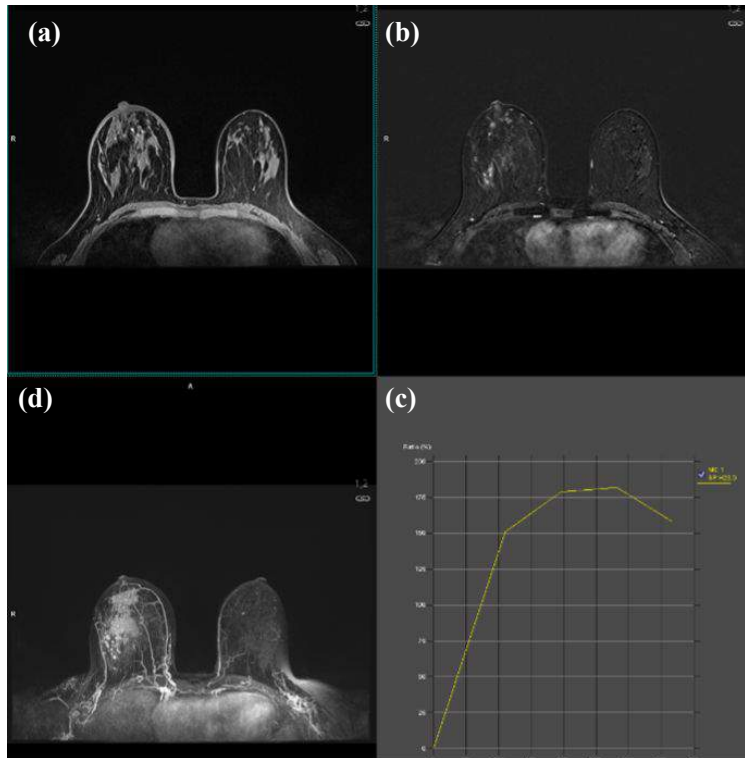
MRI image of a patient 42 y.o. Breast MRI T1-weighted (a), (b) T1 SUB after C (which means T1-weighted images acquired after the administration of a contrast agent, with subtraction performed to enhance the visualization of areas showing contrast uptake.), maximum intensity projection (MIP) images (d) and enhancement curve (c) from the tumor. The right breast extended tumor comprises outer quadrants and the borders of the quadrants. In the bottom right, the tumor enhancement curve between the time (x-axis and the signal intensity (y-axis) demonstrates a wash-out pattern, indicating a specific type of contrast uptake and clearance behaviour. Examination performed in Breast Diagnostic Imaging Unit, Diagnostic Imaging Department, University Hospital in Cracow (Pracownia Diagnostyki Obrazowej Piersi Zakładu Diagnostyki Obrazowej Nowego szpitala Uniwersyteckiego w Krakowie).
